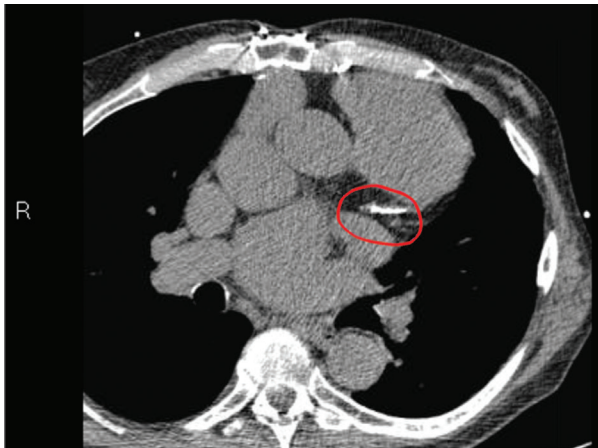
Non-contrast CT Angiography showing calcification and stenosis of Left Anterior Descending (LAD) artery
